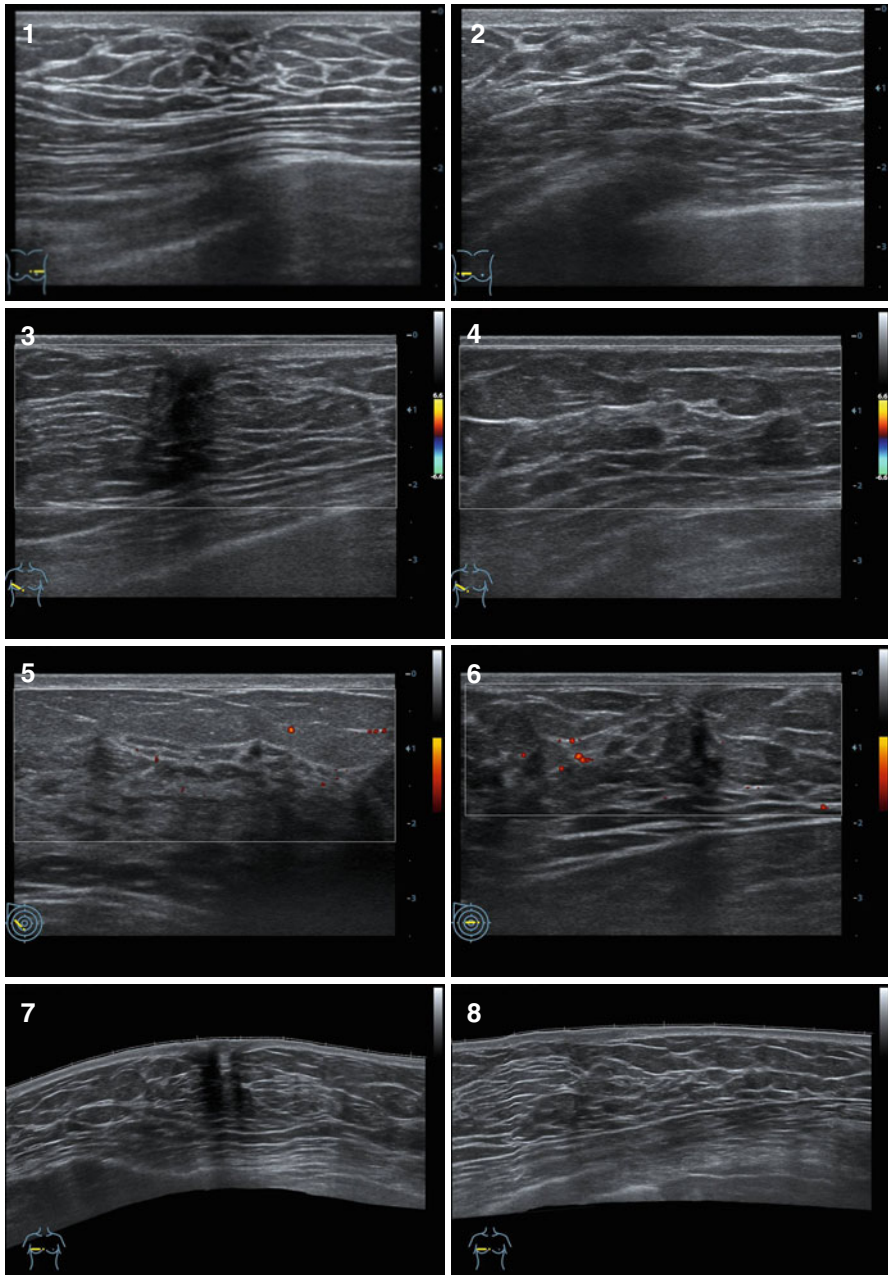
(1–14) Healthy male breast. Grayscale US, color Doppler imaging (CDI), power Doppler imaging (PDI), panoramic scan, compression elastography, and strain ratio
